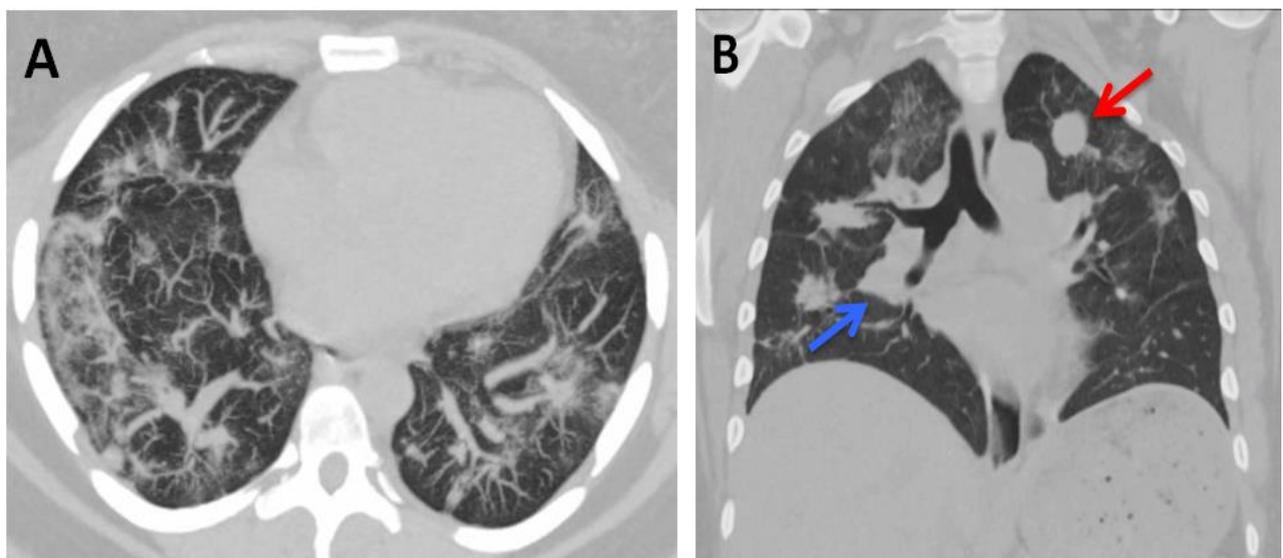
CT of the chest without contrast. A) Diffuse patchy opacities in both lungs. B) Well-circumscribed masslike soft tissue nodule in the left lung apex (red arrow) and a masslike opacity in the right perihilar region (blue arrow).
